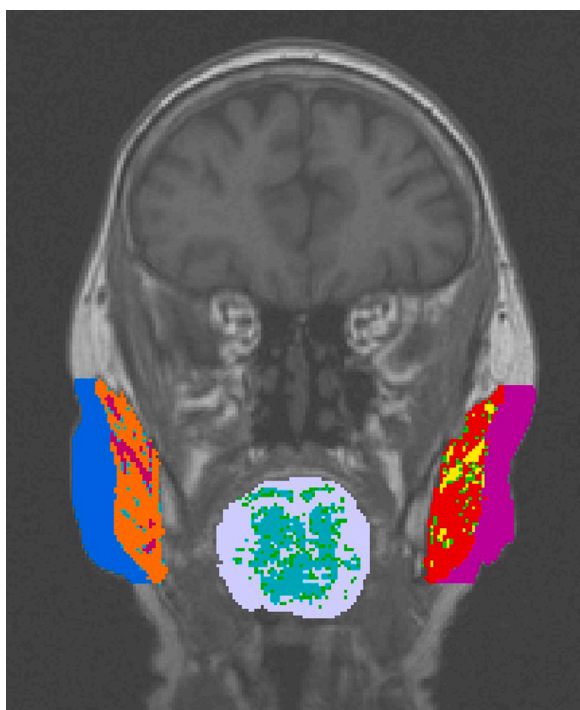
Segmented cerebral MRI slice in which the muscles and intramuscular fat (iMAT) of the tongue and right and left subcutaneous fat, masseter muscles, and masseter iMAT have been tagged with different colours for quantification.
